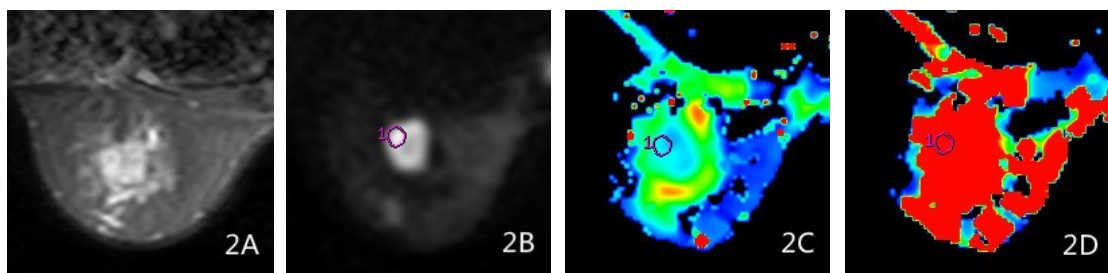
The images of MRI scanning for patients with grade II breast cancer. Fifty-two years old female patients with left breast invasive cancer at grade II. (2A) T2WI sequence of fat suppression. (2B) The corresponding gray-scale image when selecting ROI. (2C, 2D) The IVIM parameters of this patient: $D\text{-mono} = 0.00231$; $D^*\text{-mono} = 0.00921$; $f\text{-mono} = 0.30531$; $D\text{-bi} = 0.00071$; $D^*\text{-bi} = 0.03691$; $f\text{-bi} = 0.33916$.
